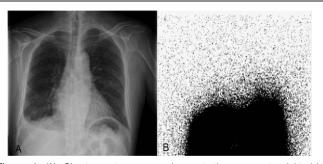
(A) Chest roentgenogram demonstrating an acute right-side hydrothorax. (B) The result of Tc-99m MAA was negative. Tc-99m MAA = technetium-99-labeled macroaggregated albumin.
